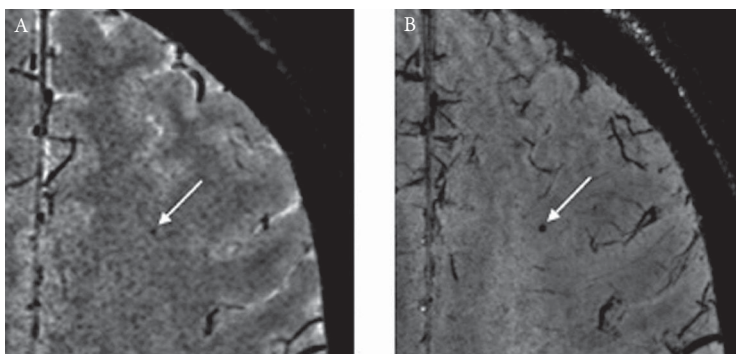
(A) A 1.5-T magnetic resonance image shows a hypointense lesion (arrow) that was hard to distinguish from noise and was not scored as a microbleed. (B) On 7-T magnetic resonance imaging, this hypointense lesion is visible as a typical microbleed, showing enlargement resulting from the blooming effect. This lesion was scored as a microbleed by two different observers. (Adapted with permission from Conijn MMA. *AJNR Am J Neuroradiol*. 2011;32:1043–1049.)
